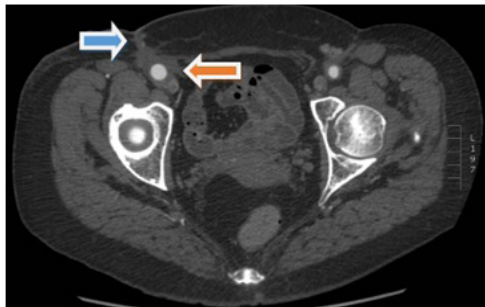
Angio-CT (axial view) showing the prosthetic right graft surrounded by an infected collection (orange arrow) along with a cutaneous fistula (blue arrow).
